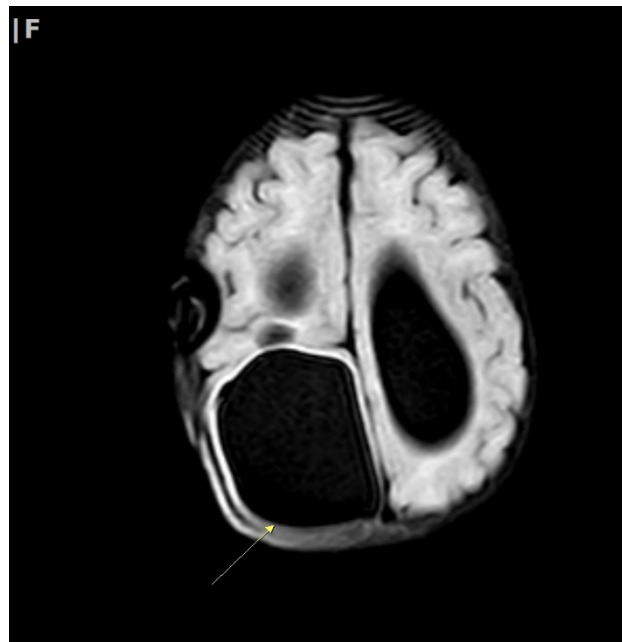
Axial FLAIR MRI shows a large low FLAIR signal intensity lesion developed adjacent to occipital horn of right lateral ventricle. The lesion demonstrates CSF-like signal intensity, appearing hypointense on FLAIR and hyperintense on T2-weighted imaging.
